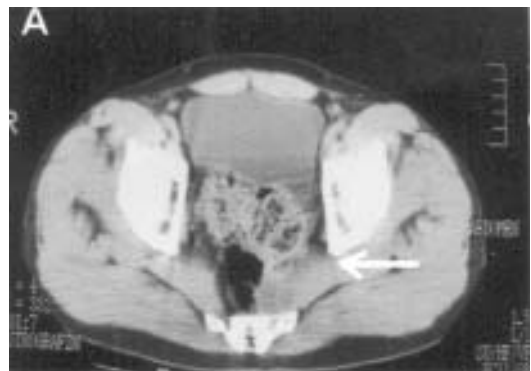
Appearance of the cystic lesion at the level of 2nd and 3rd sacral vertebra before the treatment (CT view).
